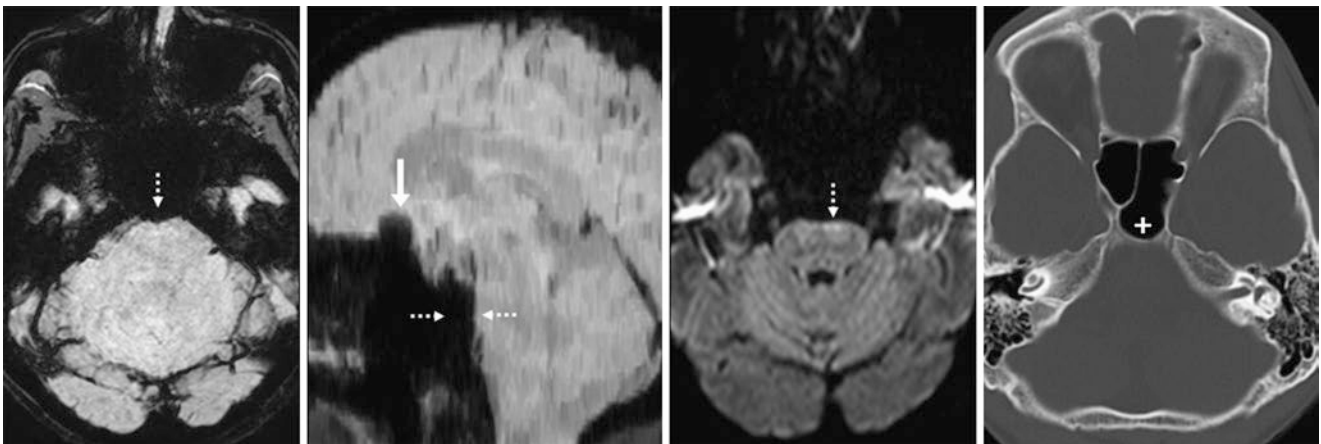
Air-bone interface artifact from the sphenoid sinus. A 34 year old with T2* effects that protrude into the prepontine cistern and brainstem (*dotted arrows*) from sphenoid sinus air, as demonstrated on 2-mm-thick SWIs at 1.5T in axial (*left*) and 5-mm-thick sagittal (*left middle*) planes. DWI (*right middle*) suffers from a similar artifact along the ventral brainstem. NECT (*right*) confirms sinus air (+), with a thin posterior sinus wall. Also, note the artifact arising from aeration of the top of the ethmoid air cells (*arrow*)
